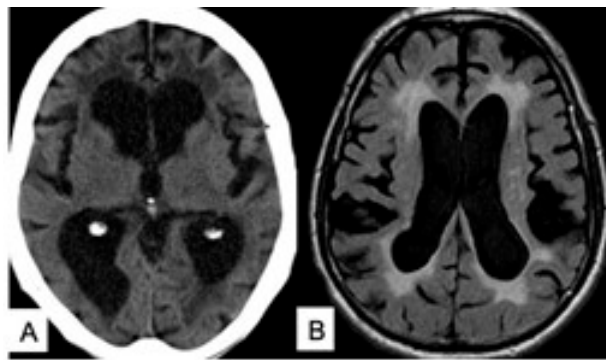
(A) CT scan showing ventriculomegaly with periventricular hypodensity suggestive of hydrostatic edema. (B) MRI scan shows ventriculomegaly with periventricular high-intensity signal suggestive of hydrostatic edema. Source: Figure by authors.
